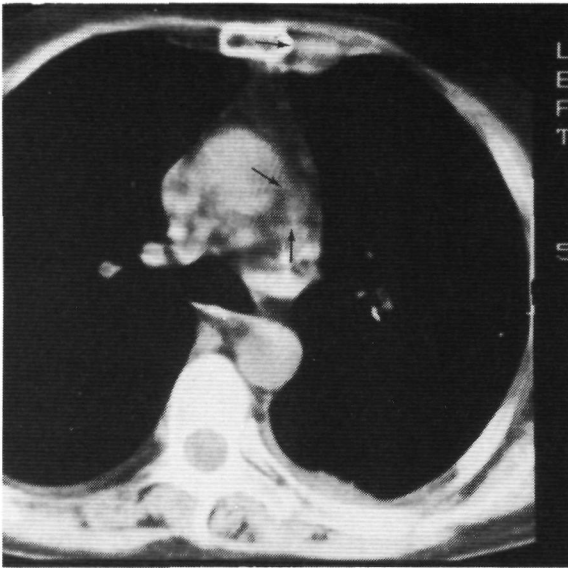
Case 3. Female patient of 63 years with HD. Chest radiograph normal. CT reveals enlarged left internal mammary nodes, and enlarged nodes in the aortic-pulmonary window. Also minimal amount of pleural fluid.
